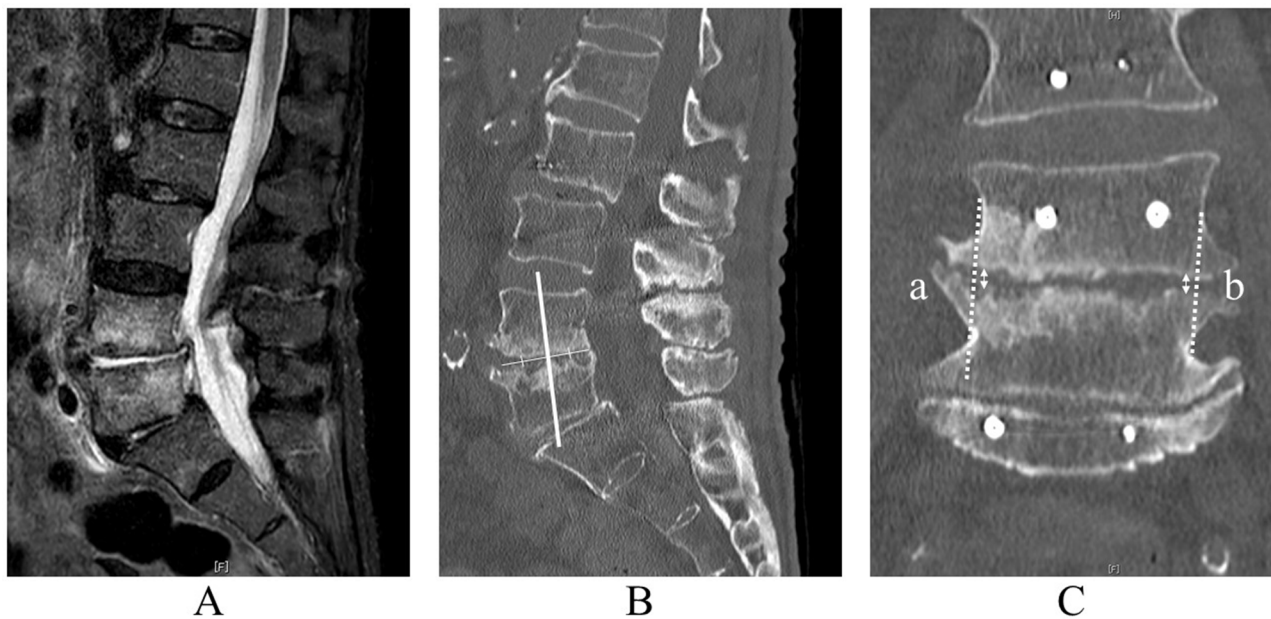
Method for measuring the distance between the infected vertebrae after surgery. A case of pyogenic spondylitis at L4/5 was shown (A, magnetic resonance imaging). The coronal plane of postoperative computed tomography was reconstructed at the center of the vertebral body (B, solid line). The mean distance between right and left endplates (C, a and b) at the outer edge of the infected vertebral body (dotted line) was measured
